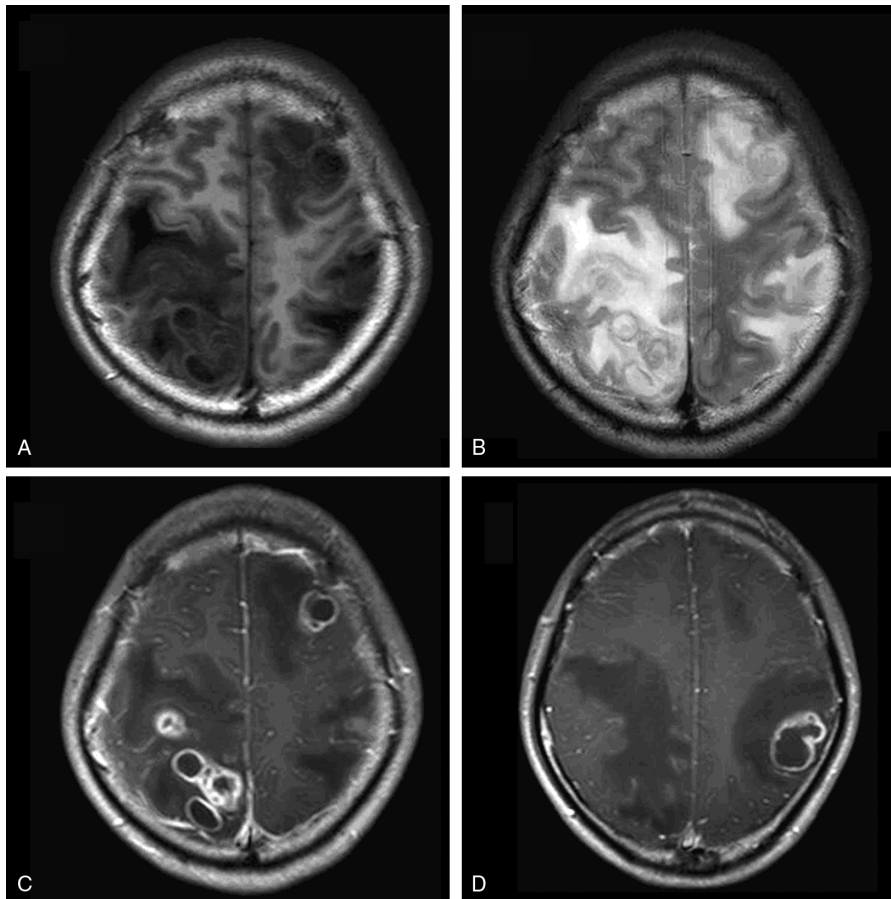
MRI found multifoci nocardial brain abscesses. (A) Axial T1-weighted image showed multiple low signal intensity lesions. (B) T2 weighting showed significant edema around the lesions. (C, D) T1-weighted contrast-enhanced image showed multifoci, ring-enhancing abscesses.
